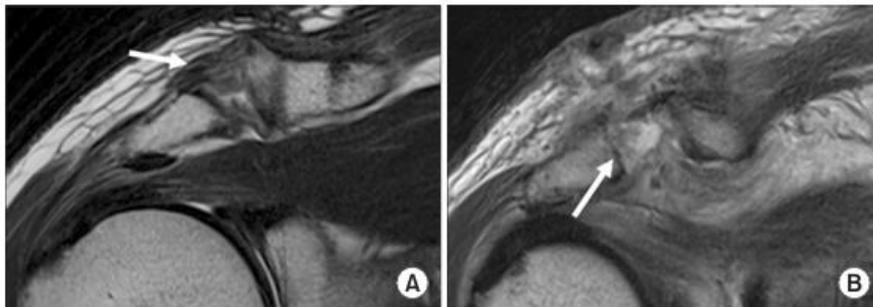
Post-hook plate removal T2-weighted magnetic resonance images. The healing grade of the acromioclavicular ligament by Ihara. (A) The white arrow shows the integrity of the healed acromioclavicular ligament complex. (B) The white arrow depicts a non-healed acromioclavicular ligament complex.
